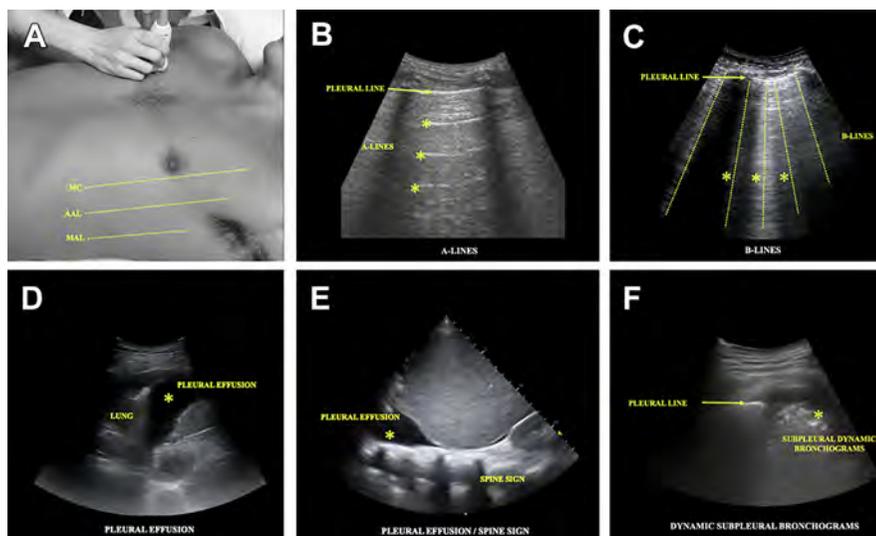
Main LUS findings. (A) Six zone scanning protocol for LUS. The left and right sides of chest wall are divided following 3 lines: mid-clavicular (MC), anterior axillary line (AAL) and mid-axillary line (MAL). (B) A-line pattern, indicating normal parenchyma (*asterisk*). (C) B-line pattern (*asterisk*) indicating increased extravascular lung water and interstitial lung syndrome. (D) Left-sided pleural effusion (*asterisk*). (E) Right-sided pleural effusion (*asterisk*). The thoracic spine vertebral bodies are seen due to enhanced transmission of ultrasound by pleural effusion.⁵⁹ (F) Subpleural bronchograms (*asterisk*) indicating lung consolidation from pneumonia. ([A] Adapted from [A] Pivetta E, Goffi A, Lupia E, et al. Lung ultrasound-implemented diagnosis of acute decompensated heart failure in the ED: A SIMEU multicenter study. *Chest* 2015;148(1):202–10; with permission.)
